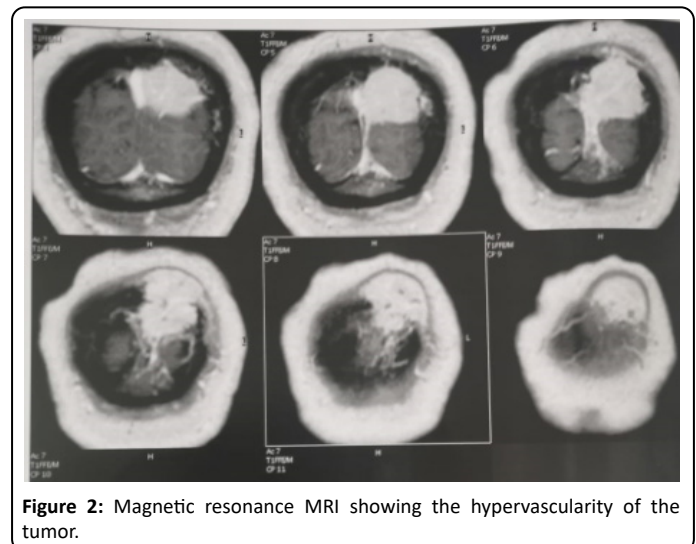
Magnetic resonance MRI showing the hypervascularity of the tumor.
